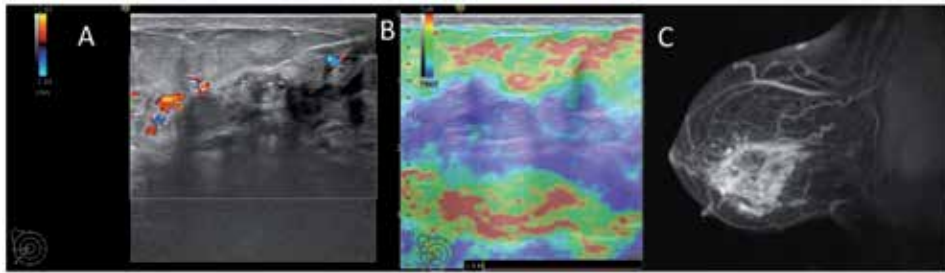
Heterogeneous US area of ILC, which is moderately vascularized and hard on elastography (AB, TS 5). The MRI (C) shows a non-mass enhancement, with a regional distribution, larger than the area predicted on US.
